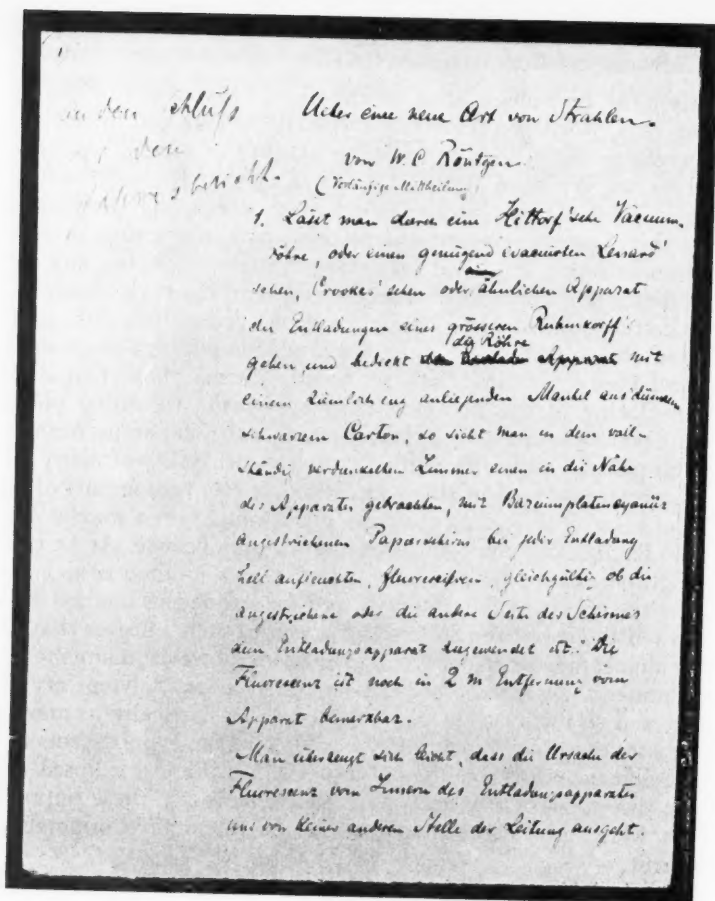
Original manuscript of Roentgen's first paper "On a New Kind of Ray." (Courtesy of the Physical Institute of the University of Wurzburg, Director, Prof. Dr. Harms.)
